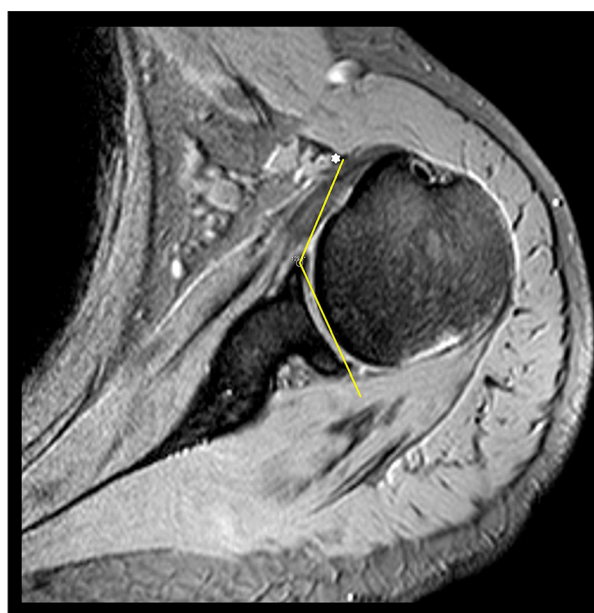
Coracohumeral distance, in axial T2-weighted FFE images (yellow\*; coracoid distal tip).
